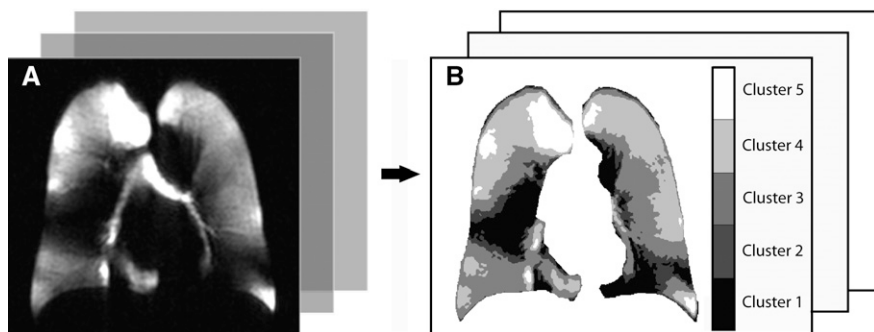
A, Coronal ^3He MR image and B, ^3He cluster map generated with semiautomated cluster analysis and segmentation for all sections. ^3He ventilation defect volume (VDV) = cluster 1, while VDP = cluster 1 normalized to thoracic cavity volume.
